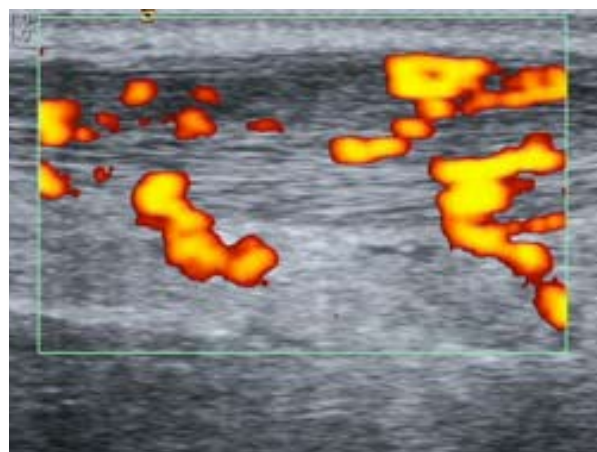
Colour Doppler ultrasound scan showing neovascularisation of Achilles tendon
